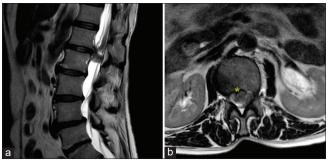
Pre-operative T2-weighted MRI sagittal (a) and axial (b) images show a "hawk-beak like" appearance at L1-L2 level, suspecting an intradural herniated disc (yellow asterisk).
